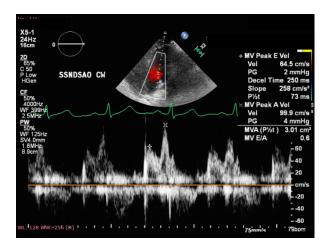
PW Doppler Echocardiography of the same patient showing grade I diastolic dysfunction (impaired relaxation). Prepared by the authors. Courtesy of the Pediatric Clinical Hospital, Lucian Blaga University of Sibiu.
